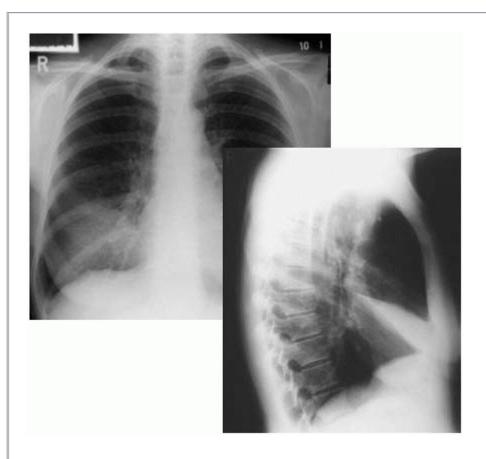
Radiographs showing right middle lobe collapse. Seen only as a slight ↑ in density to the right of the heart on the PA film. Much easierto see than on the lateral film.
